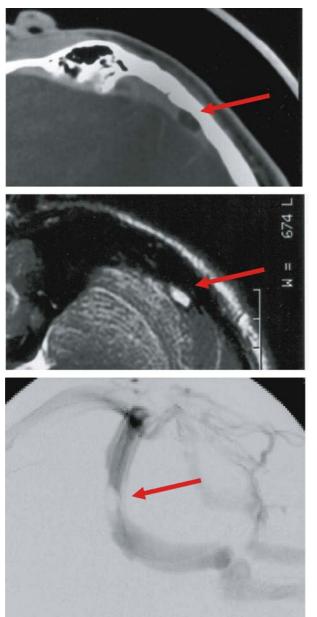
A Patient with PTS with an intrinsic lesion on venography with a pressure gradient. On review of the MR images focal lesions were demonstrated in the transverse sinuses of both sides. These may represent either large arachnoid granulations or fat within the sinuses patients; 85% were closely associated with a vein draining into the sinus. Ikushima *et al.* [70] reviewed static MR images of 1118 patients. Arachnoid granulations were present in 8.3% of males and 12.2% of females. A total of 134 arachnoid granulations were found with an overall incidence of 10%. In 14 patients there were was more than one granulation. The most common site of the granulations was the transverse sinus (85.8%).
